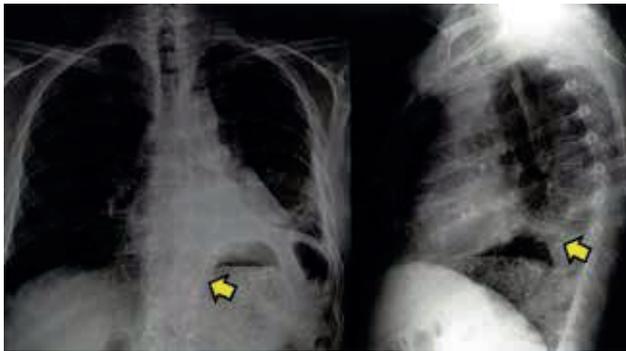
Postoperative control. X-ray. Postoperative radiologic pair without incidences. Complete pulmonary re-expansion of the culmen. The image corresponding to the correctly positioned aortic prosthesis are identified with arrows.
